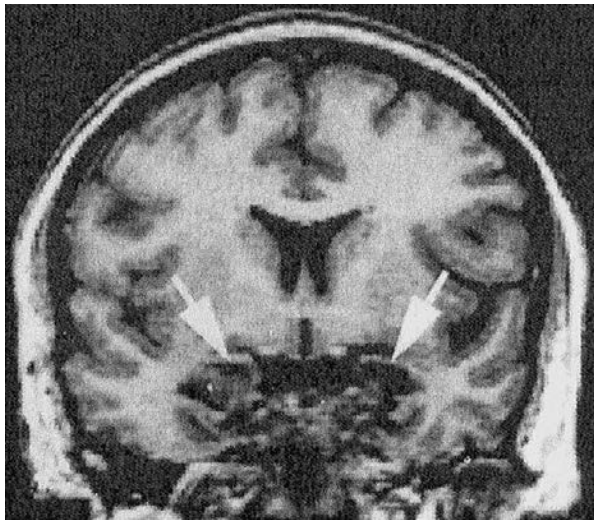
T_1 -weighted MRI image showing a coronal slice through the brain of a patient with Urbach–Wiethe disease. Arrows indicate loci where the amygdala would normally be found. (Adapted from Adolphs et al., 1995.)
